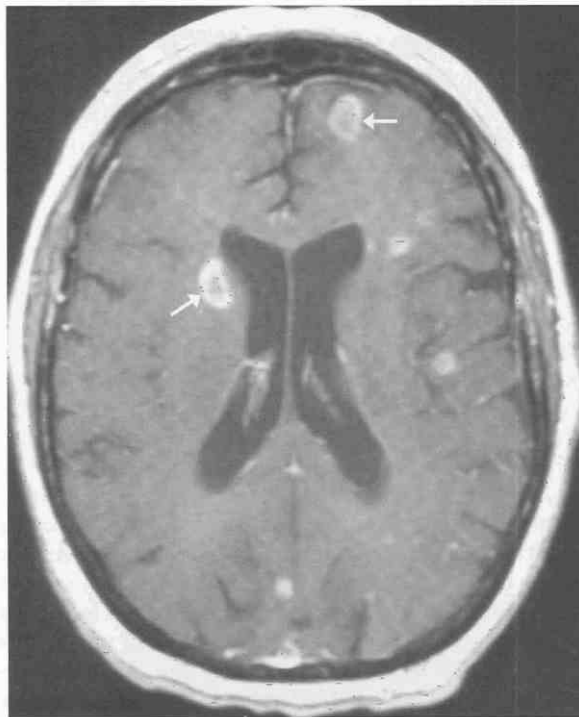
Hematogenous metastases of small cell carcinoma of the lung to the brain. Axial T1-weighted postgadolinium image demonstrates multiple contrast enhancing ring and ovoid lesions of varying size (arrows) at the junction of gray and white matter in both cerebral hemispheres. Although numerous, these tumors are relatively small and have not yet provoked grossly evident surrounding white matter edema.
